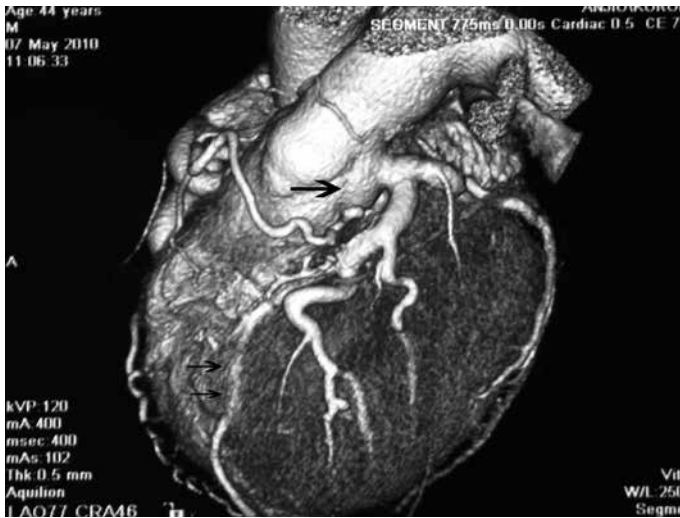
Multislice computed tomography angiography view of left main coronary artery arising from the pulmonary artery and muscular bridging in the left anterior descending artery (angiography)
